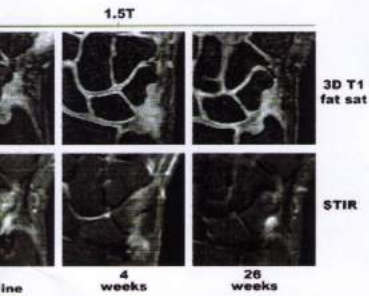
MRI scans showing erosions (arrows) in the metacarpal head between baseline and 26 weeks. The baseline 0.28T 3D T1 sequence showed an erosion (arrow) at 26 weeks which was not well delineated on the 1.5T 3D T1 sequence.
